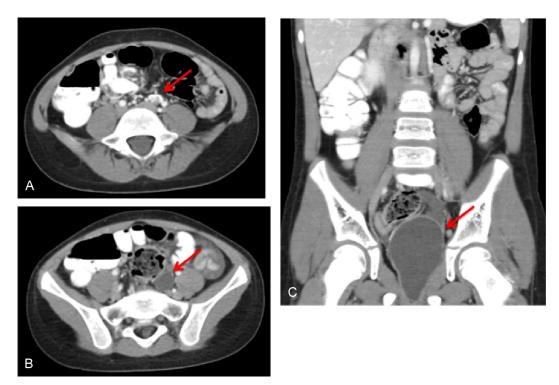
CT scan showing contrast enhancing left pelvic renal remnant (arrow, A), dilated left ureter (arrow, B), dilated left hemivagina (arrow, C). (Color version available online.)
